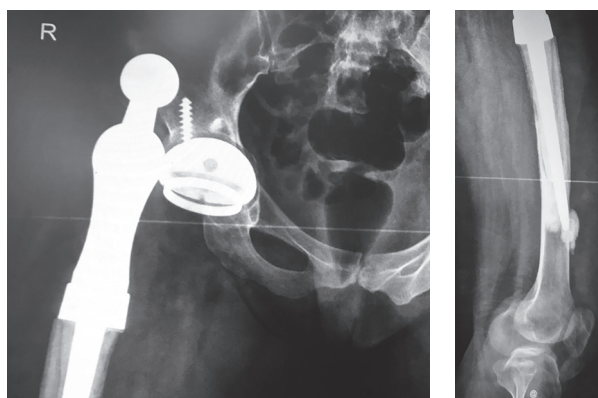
X-ray of the right hip joint. The line of enlightenment is determined at the border of bone-cement (stem) and bone-implant (cup). The distal end of the stem perforates the femur, where the bone cement is visible
